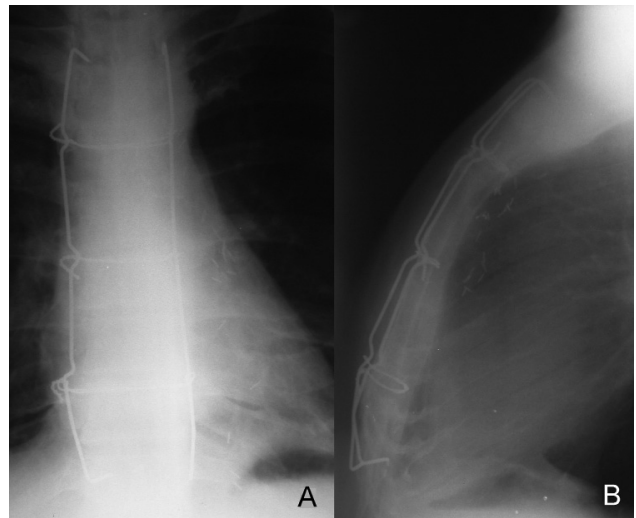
A, Roentgenogram showing the posteroanterior view of the sternum postoperatively. B, Roentgenogram showing the lateral view of the sternum postoperatively.
